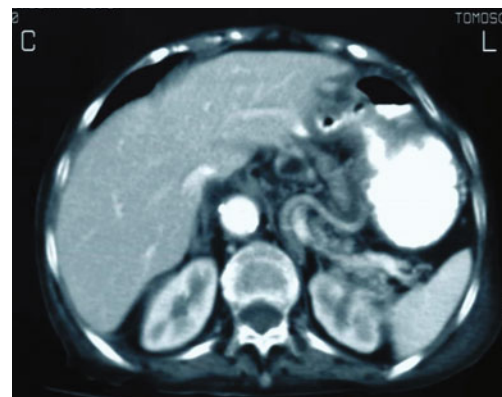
Abdominal computed tomography demonstrating a mass in the lesser curvature of the stomach, without any secondary metastases in the liver.
